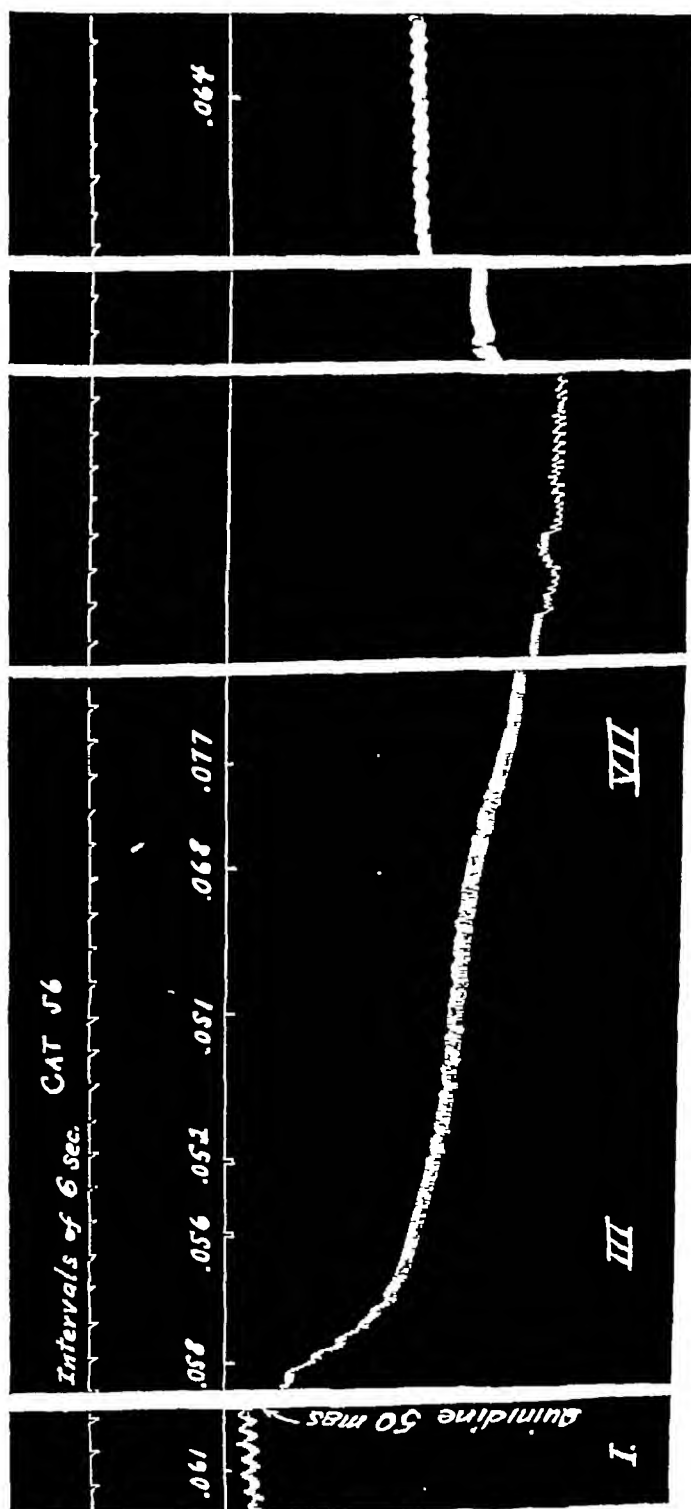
CAT 56 WEIGHT, 2.3 KG. NUMERALS SHOW WEIGHT OF X-RAY SILHOUETTES TAKEN AT MOMENT INDICATED BY SIGNAL JUST BELOW
